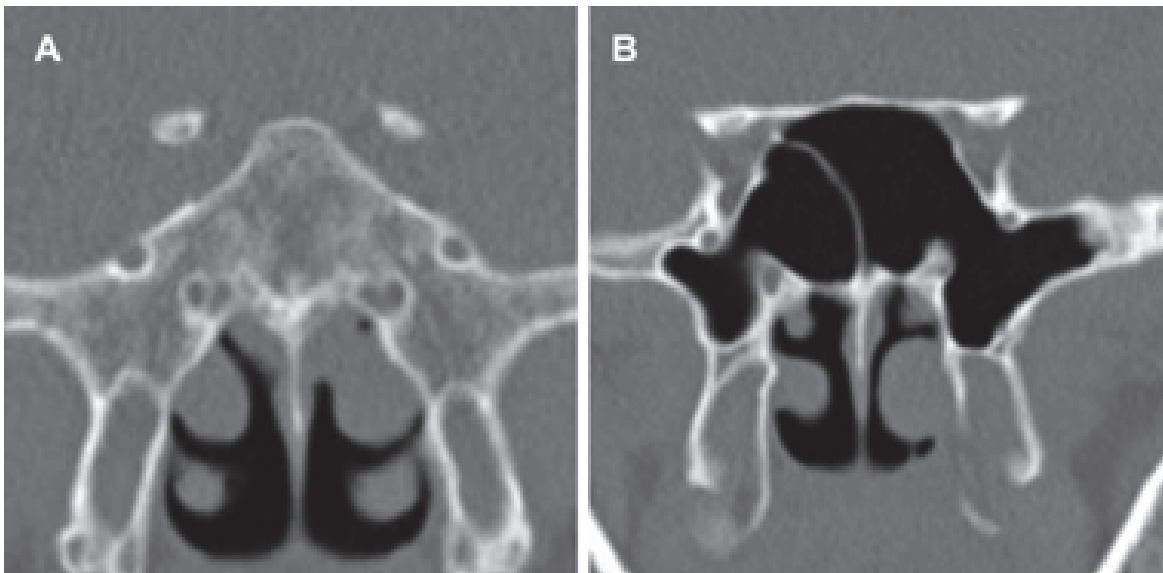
Coronal CT slices showing the different type of sphenoid sinus pneumatization. A: conchal type. B: sellar type.
